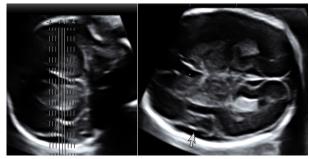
The Sylvian fissure (arrow). 3D ultrasound – multiplanar mode.
